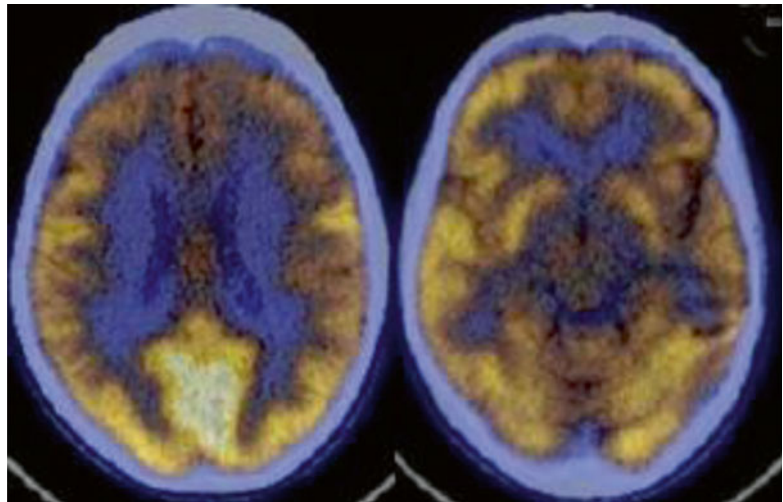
Transaxial fused F-18-FDOPA image (*left*) showing decreased tracer uptake in caudal left putamen in a case of CBS symptomatic on the right side. Transaxial fused ¹⁸F-FDG PET-CT image (*right*) of the same case of CBS; hypometabolism is noted in the left parietal cortices
